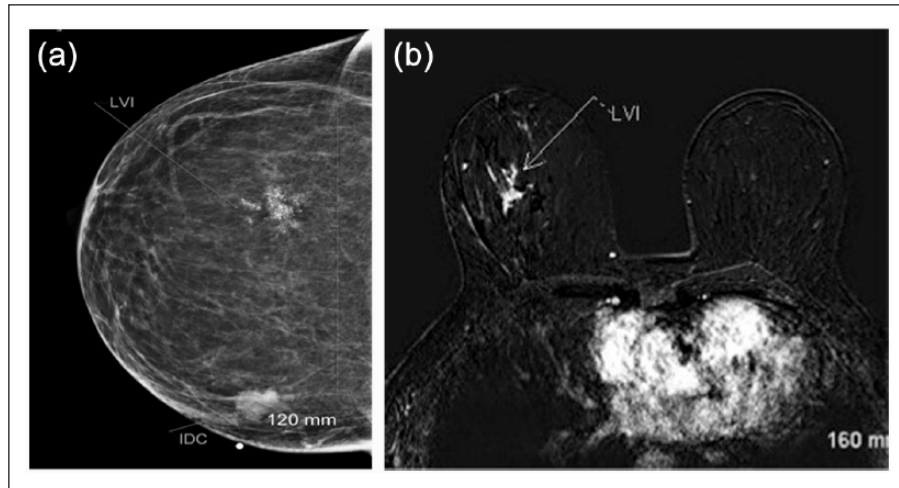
(a) Right CC view showing medial invasive cancer and upper outer quadrant microcalcifications suggesting DCIS and (b) contrast-enhanced MRI showing clumped, linear enhancement in the right upper outer quadrant at the site of microcalcifications, suggesting DCIS but shown pathologically to represent LVI.
